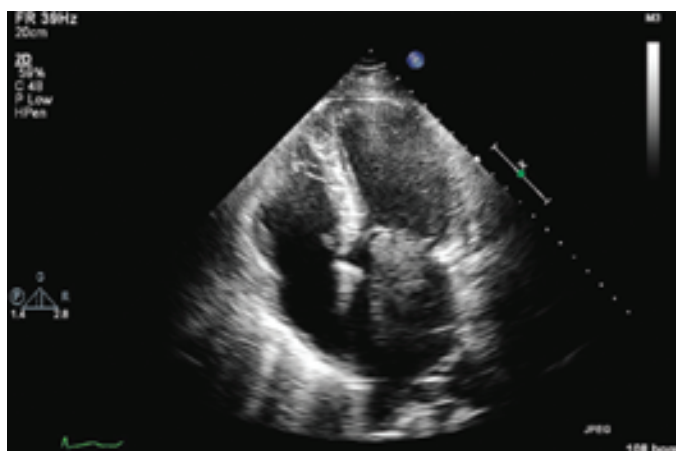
Image from a transthoracic echocardiogram confirmed the presence of a left atrial mass directly adjacent to the anterior leaflet of the mitral valve.
